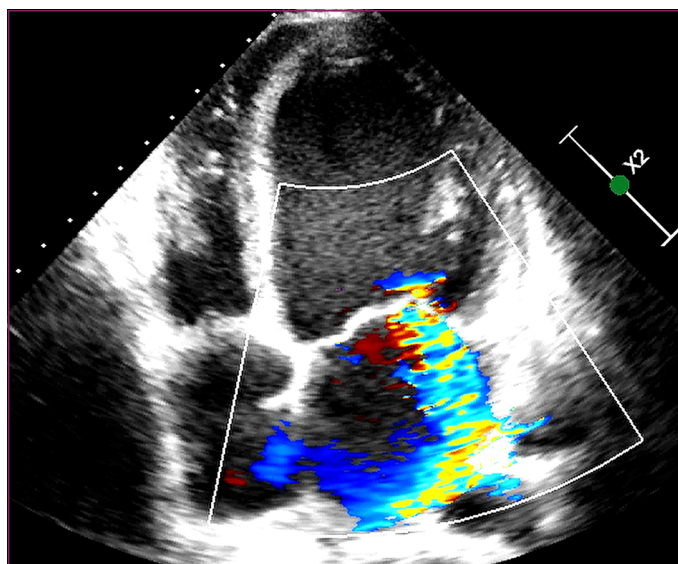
Transthoracic echocardiography (TTE) demonstrated severe left ventricular dysfunction (EF: 25%), global hypokinesia, and moderate mitral regurgitation, with normal right ventricular function.
